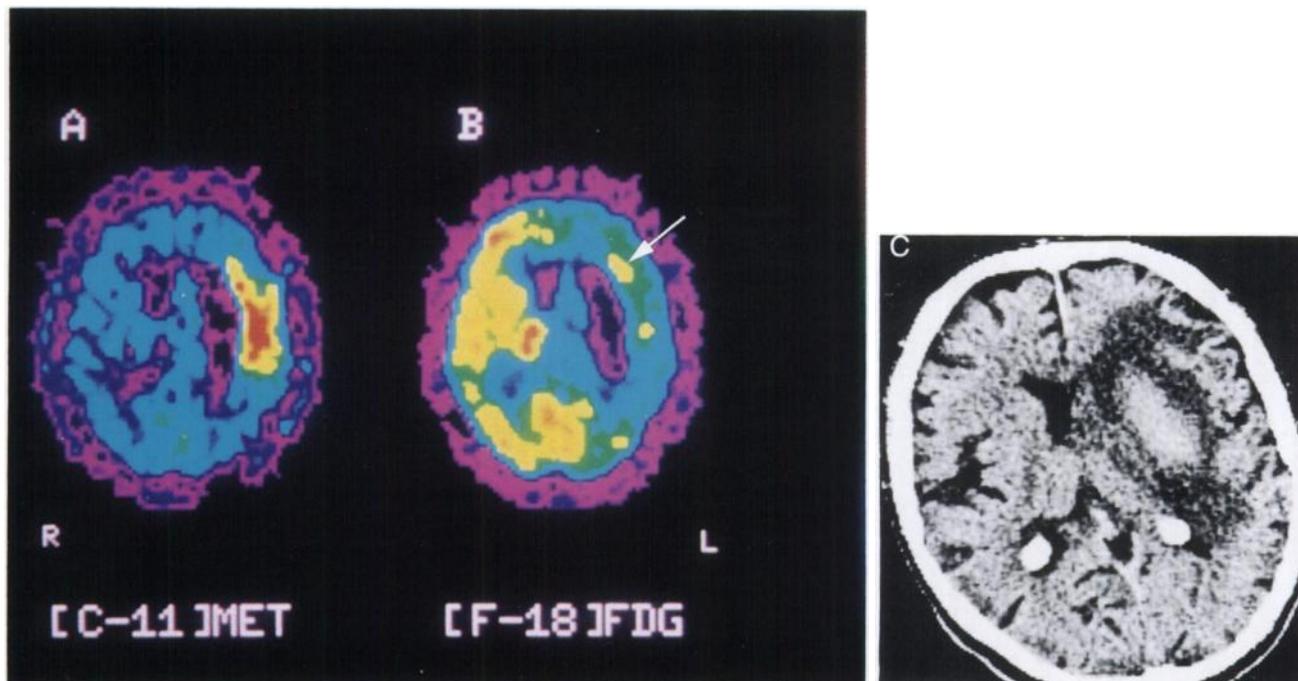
Patient 2. (A) Carbon-11-methionine PET image obtained 20 days after the hemorrhage shows high uptake of the tracer in the area surrounding the left putamino-capsular hematoma (right part of the image). (B) FDG PET image shows discrete spots of moderate uptake of the tracer next to a hypometabolic area (right part of the image). The arrow points at one spot of FDG uptake within the boundary of increased uptake of ^{11}C -methionine. (C) CT at a level similar to the PET image shows a spontaneously hyperdense lesion in the left putamino-capsular area.
